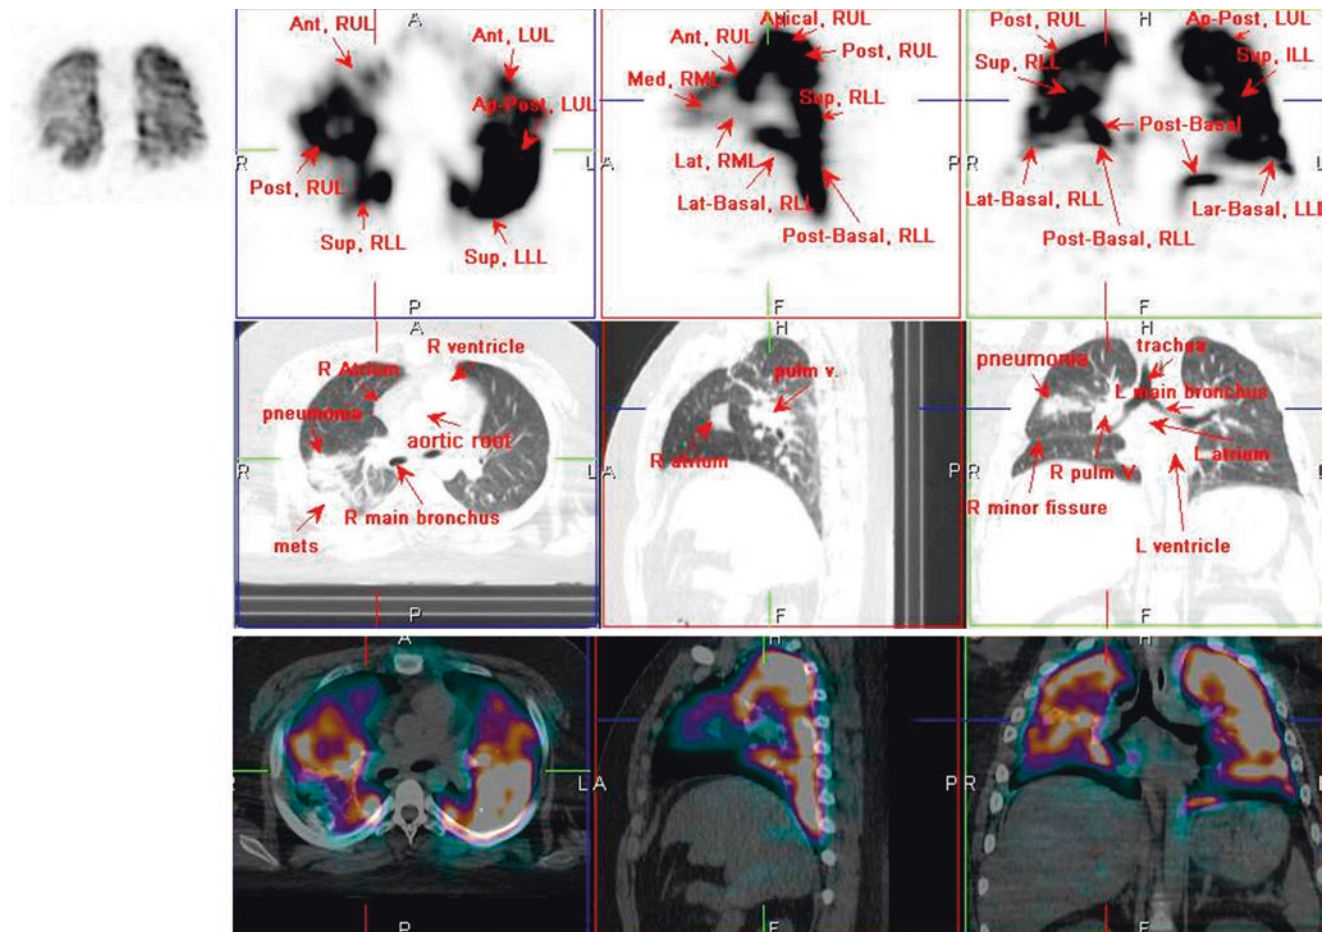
^{99m}Tc-MAA SPECT/CT
